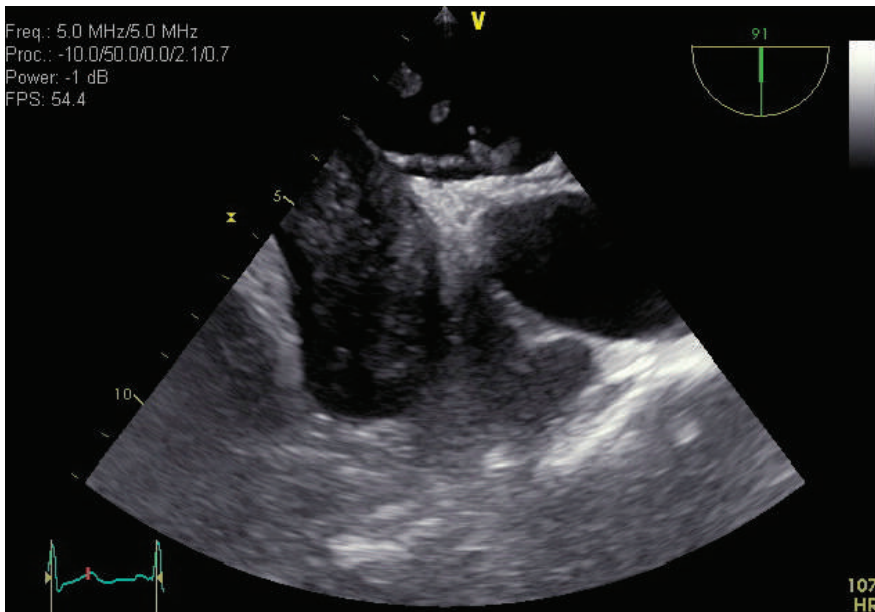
Transesophageal echocardiography biatrial view, showing echodensity in the right atrium traversing through an atrial septal defect into the left atrium.
